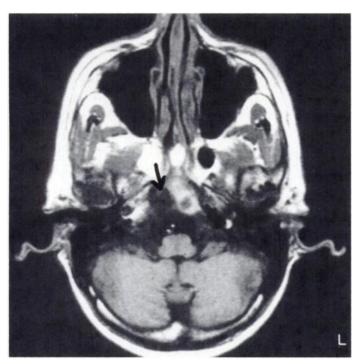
MRI scan of Patient 1 shows bone involvement of the skull base at the right side just posterior to the sphenoid sinus (arrow).
